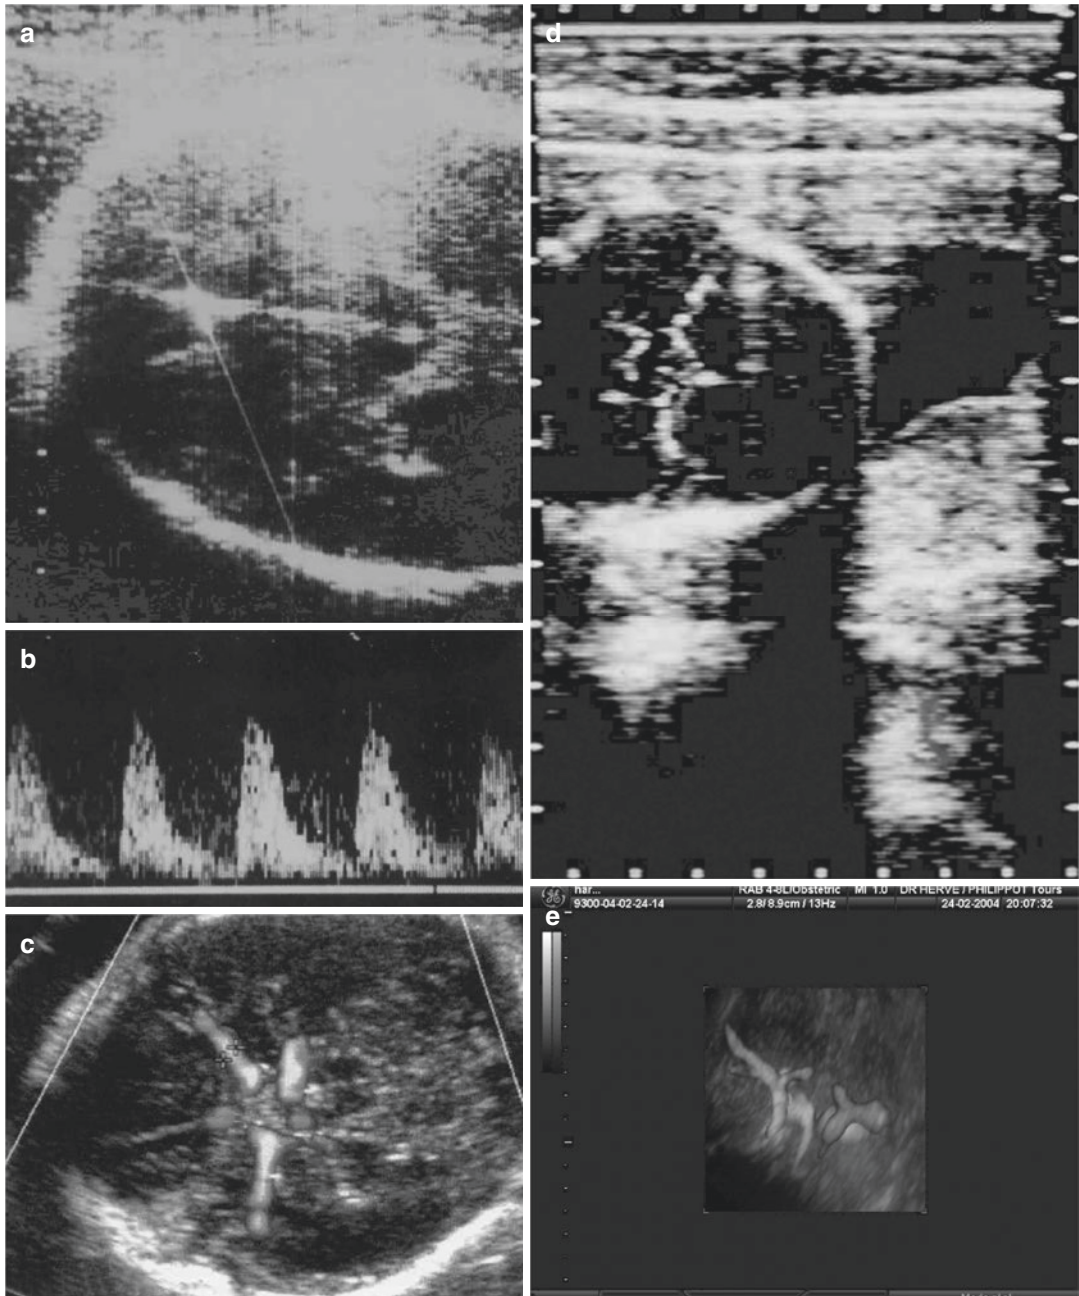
Investigation of the fetal cerebral arteries. (a, b) Fetal cranial cross section with the cerebral peduncle and the Doppler sample volume on the anterior cerebral arteries and the corresponding Doppler spectrum (1986). (c, d) Color Doppler of the circle of Willis (1988). (e) Three-dimensional color Doppler (2004) [22]
